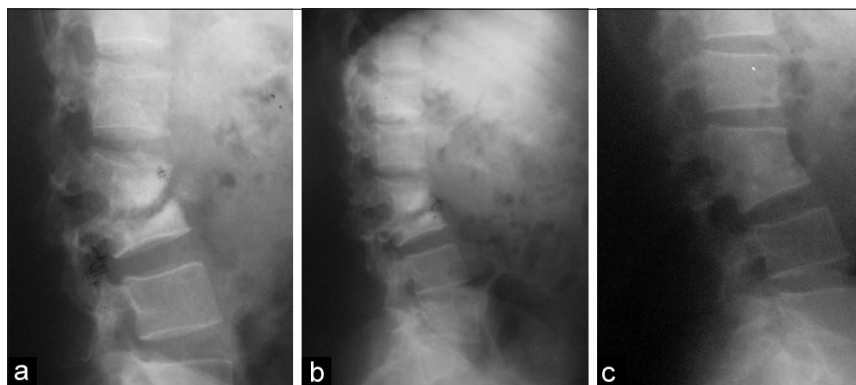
Sequential series of X-rays in a 50 year old female with thoracolumbar TB (a) at presentation, (b) at 4 months and at 10 months, (c) showing the destruction of the joint space and erosion of the endplates initially followed by bony fusion and bone block formation by around 9 months of DOTS. This patient had an atypical sclerotic appearance, however the diagnosis was confirmed by a CT guided biopsy
